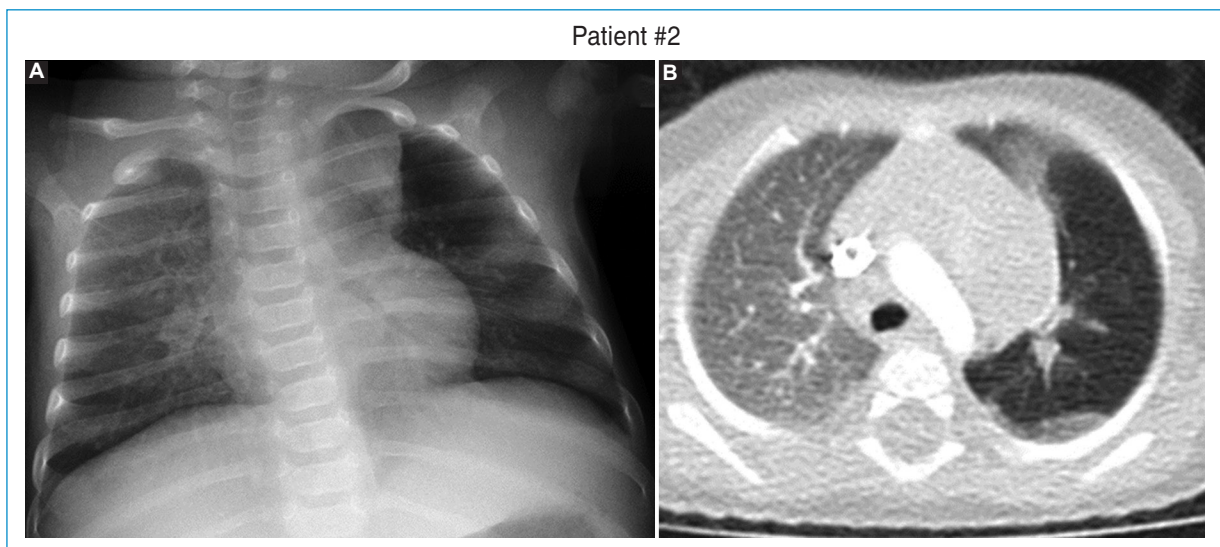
A: chest X-ray: hyperlucent LUL, with no mediastinum shift. B: CT scan: single CLE with small parathymic atelectasis; no mediastinal shift.
